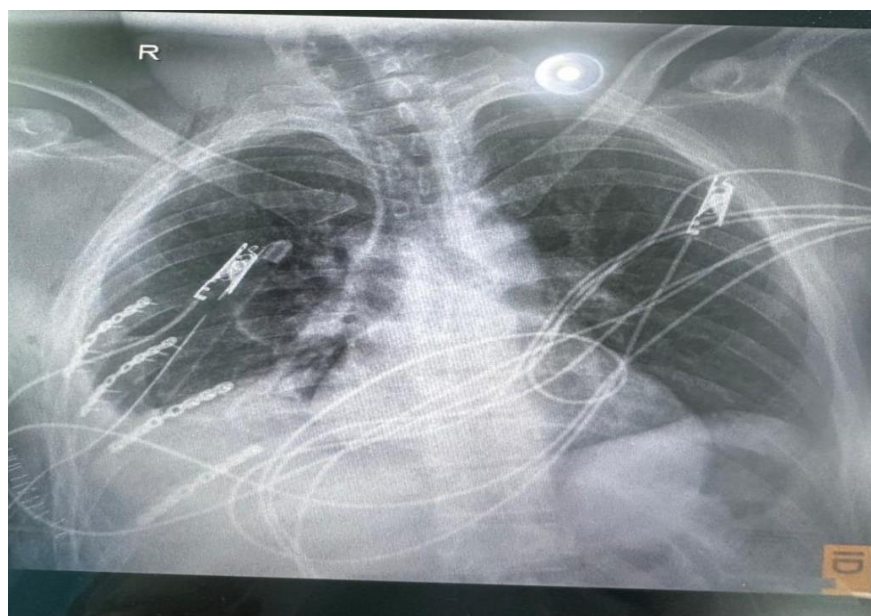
The postoperative chest X-ray shows multiple fixation plates and screws along the right side of the chest wall, consistent with surgical stabilization of rib fractures. The hardware appears well aligned with no visible displacement or hardware complications. Lung expansion on the right side has improved compared to preoperative appearance, although residual parenchymal haziness is present, likely representing contusion or postoperative changes. No obvious pneumothorax or large pleural effusion is seen.
